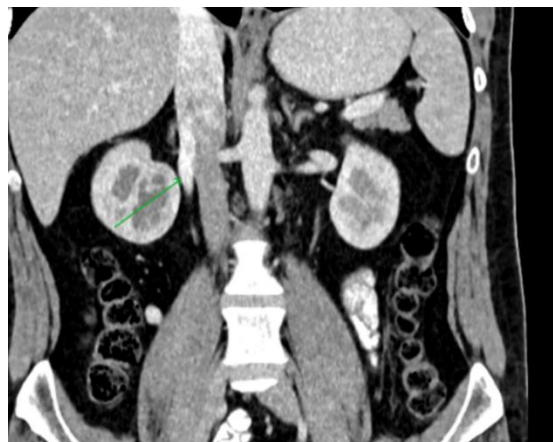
Coronal CT tracing the cortical vein (arrow) descending to join the dilated gonadal vein
